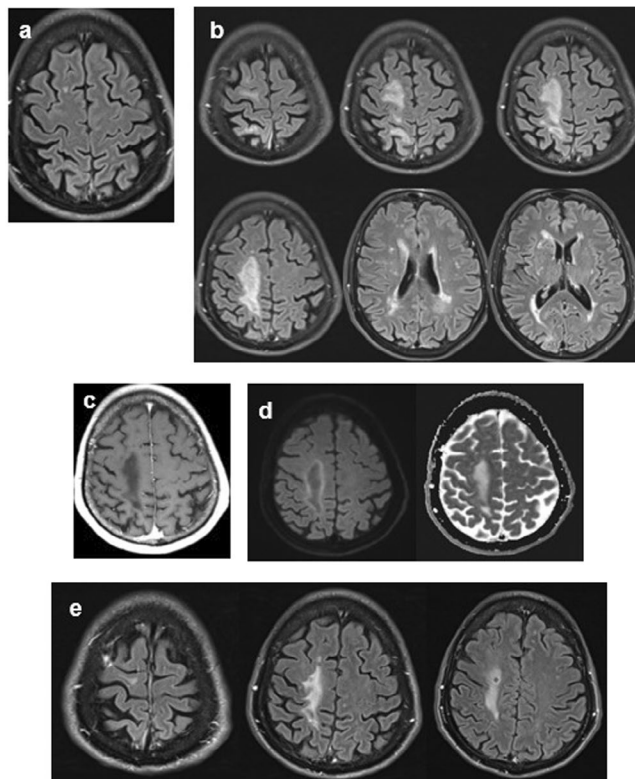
Case 1. Baseline brain MRI (a). Right fronto-parietal juxtacortical white matter lesion hyperintense on FLAIR (b), with no contrast enhancement (c) and mild peripheral diffusion restriction on DWI (d). Reduction in size in follow-up MRI (e).
